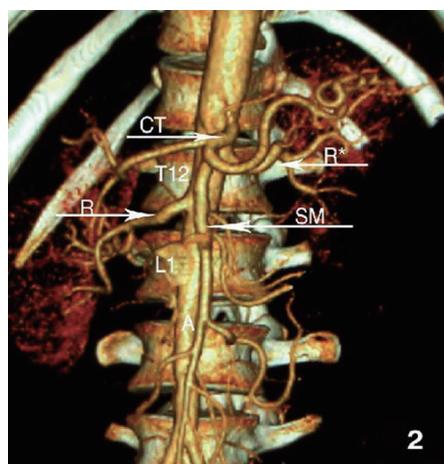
3-D MDCT angiography of abdominal aorta (A) and its branches, celiac trunk (CT), right renal artery (R) emerges at the lower level of L1, left renal artery (R*) origin at the upper level of L1 as a unique case above the level of the right renal artery and at the same level of the superior mesenteric artery (SM).
